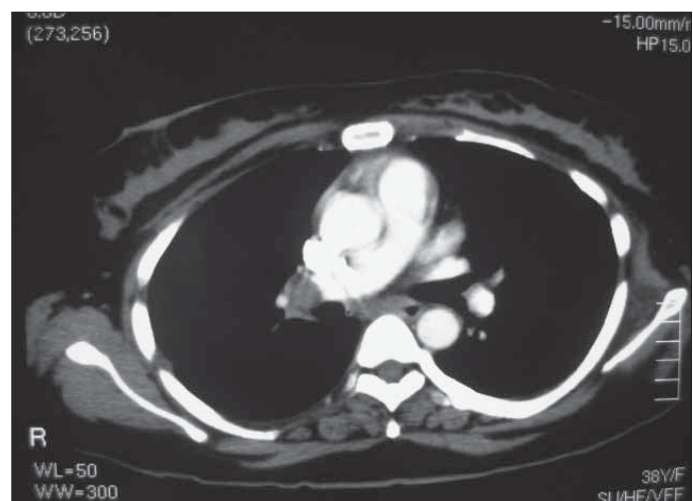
Multiple thrombi was diagnosed in the bifurcation of pulmonary artery on thoracic angio CT
